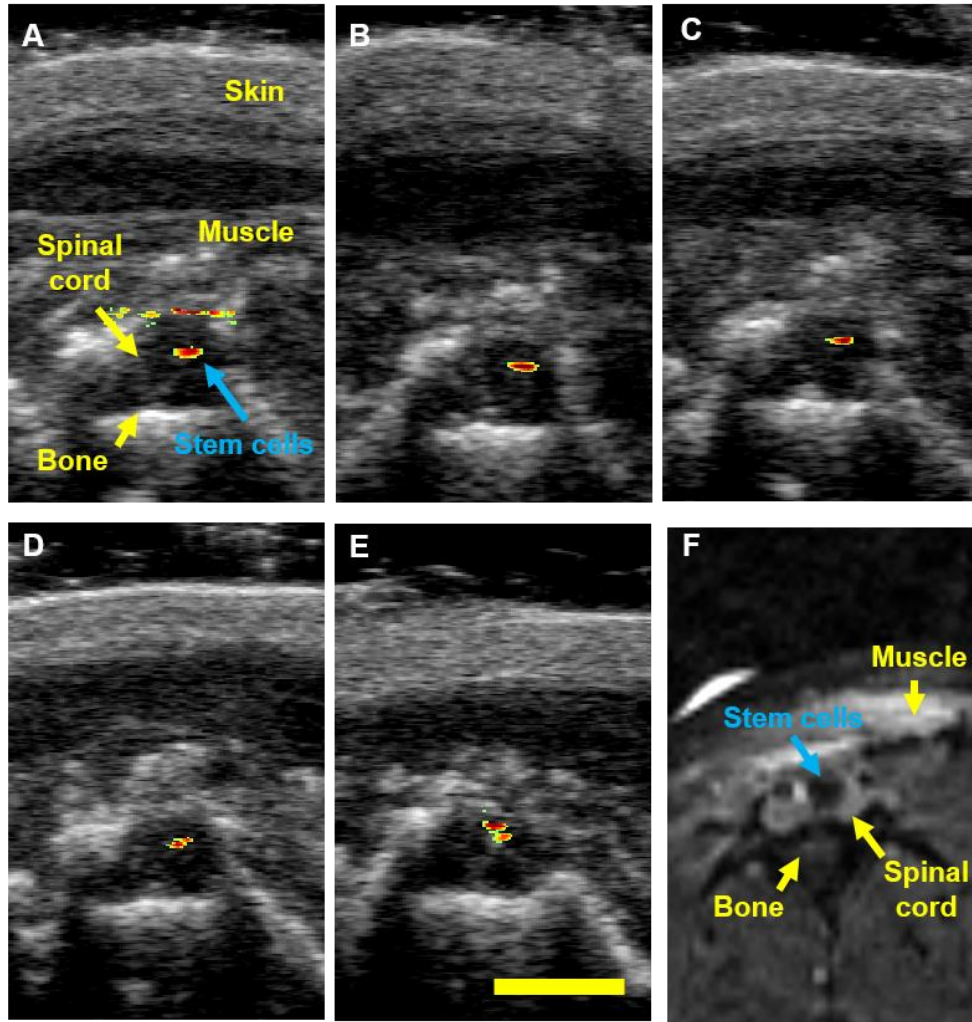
Longitudinal monitoring of PBNC-labeled MSCs *in vivo* – axial views. Post-operative combined ultrasound (grayscale) and PA (color scale) images were acquired using at 20 MHz transducer at 740 nm wavelength at 3, 5, 7, 10, and 14 days, respectively (A – E). PBNC-labeled MSCs were still visible at day 14 with PA imaging (E). T2-weighted MR images confirmed presence of PBNC-labeled MSCs (F). Scale bar = 3 mm.
